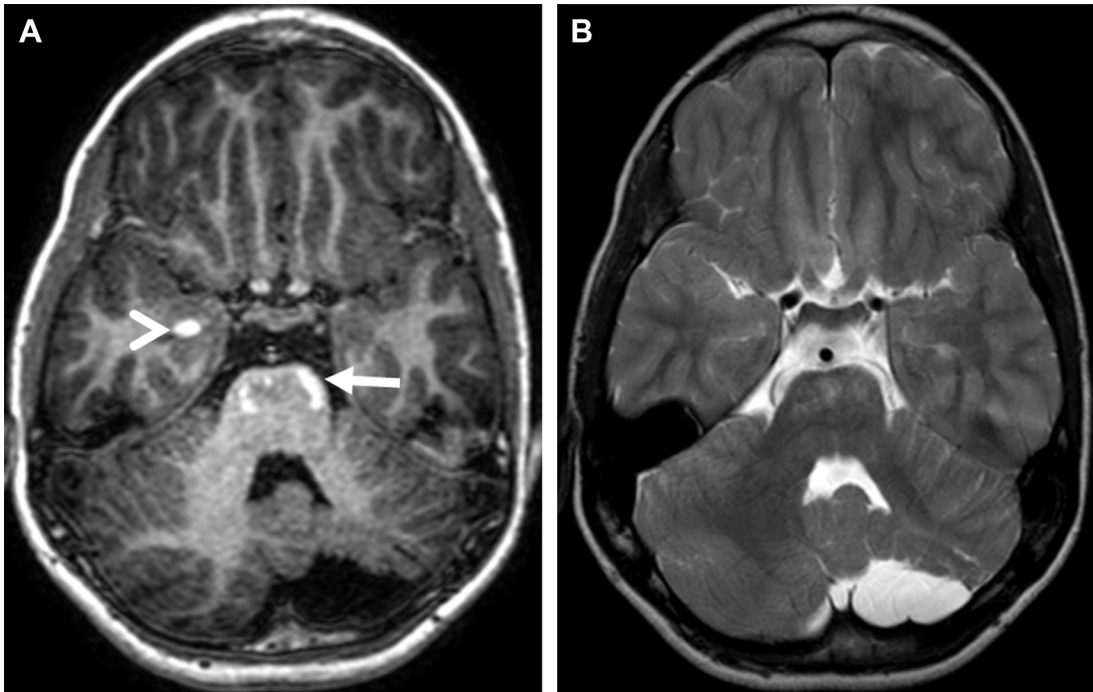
NCM. (A) Axial T1-weighted image demonstrates hyperintense signal in the anterior aspect of the pons (*arrow*) and right mesial temporal lobe (*arrowhead*) consistent with NCM. Cerebellar hypoplasia is shown on the left. (B) Axial T2-weighted image showing cerebellar hypoplasia on the left with volume loss in a normalized posterior fossa.
